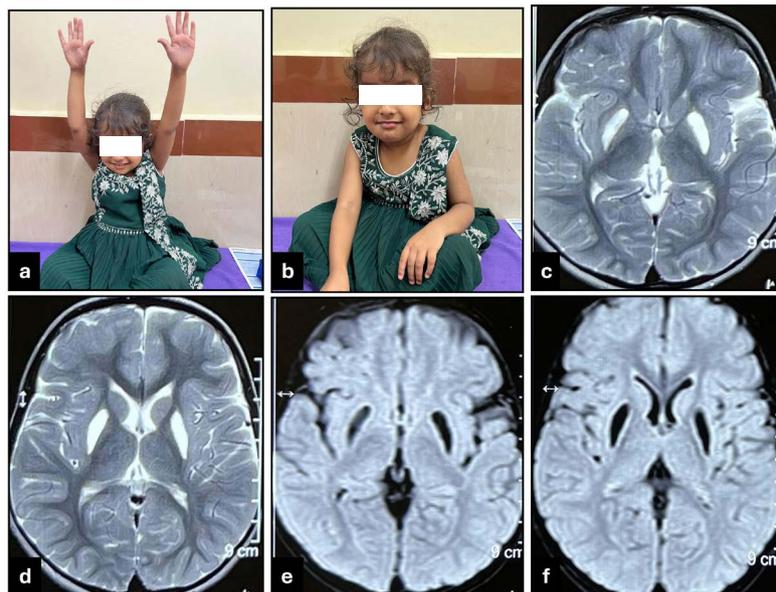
A three-year-old girl, seen during a follow-up visit at the child neurology clinic, with a significant sentinel event of acute encephalopathy, metabolic acidosis, and hyperlactatemia requiring a prolonged stay at the critical care unit at 3 months of age. Subsequently, she had lost all her milestones, only to regain them over the next 3 years with a metabolic cocktail and physiotherapy. Currently, she is ambulatory without support, albeit with an abnormally wide gait. She faces minor difficulty in performing activities of daily living due to dystonia (a and b). MRI Brain obtained 3 years after recovering from the encephalopathic crisis. Axial T2WI (c and d) shows bilateral symmetric, homogenous hyperintense signal changes involving the putamen. T2-FLAIR (e and f) shows symmetric hypointensity in the corresponding areas of T2 hyperintensities (c and d) involving bilateral putamen, suggestive of gliosis.
